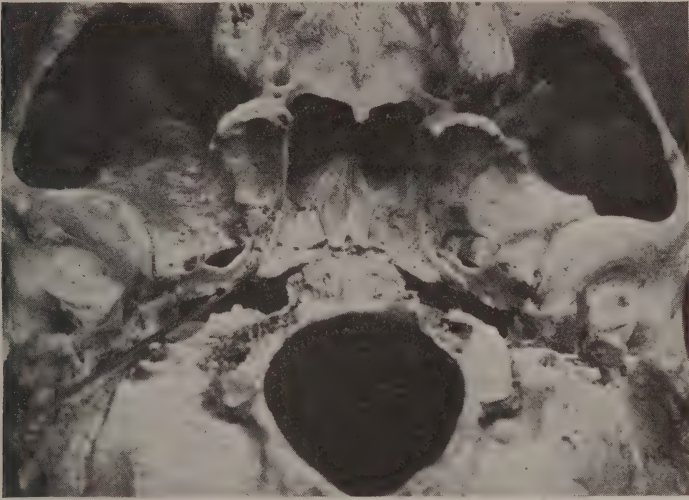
Carotid canals converted into carotid groove by enlargement of the internal carotid artery. This view indicates the relation in the mentovertical roentgenogram.
